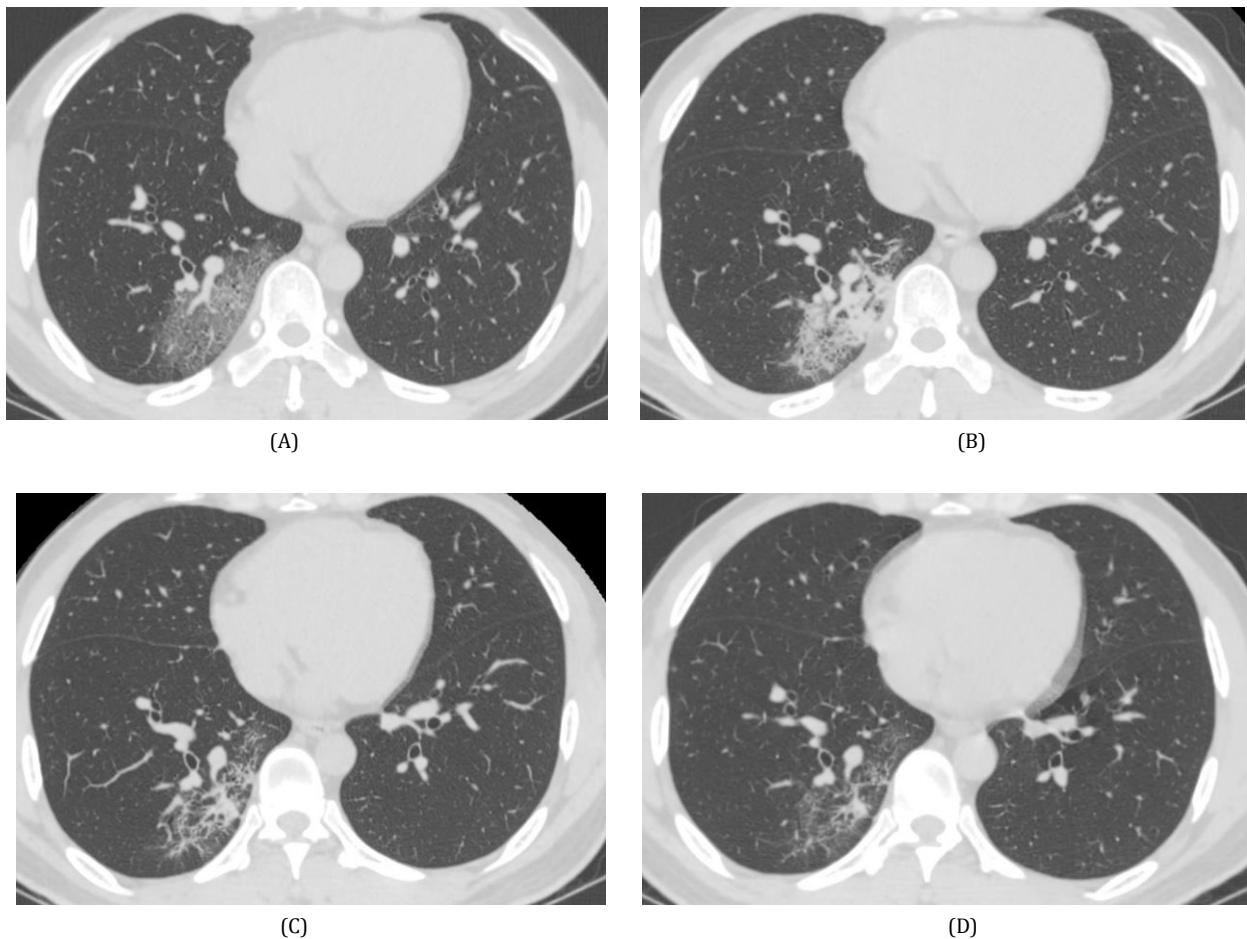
A 42-year-old male patient with COVID-19. The first computed tomography scan demonstrated flaky GGO with thickened blood vessels and slightly thicker leaflet intervals (A). The second computed tomography scan showed thickened lobular intervals, a typical crazy-paving sign, and the solid area had increased (B). The third and fourth computed tomography scans showed that the lesions were mainly fibrous strip shadows (C-D).
